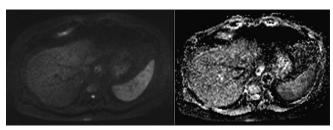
Axial diffusion-weighted imaging (B = 600) and apparent diffusion coefficient map of initial magnetic resonance imaging liver
